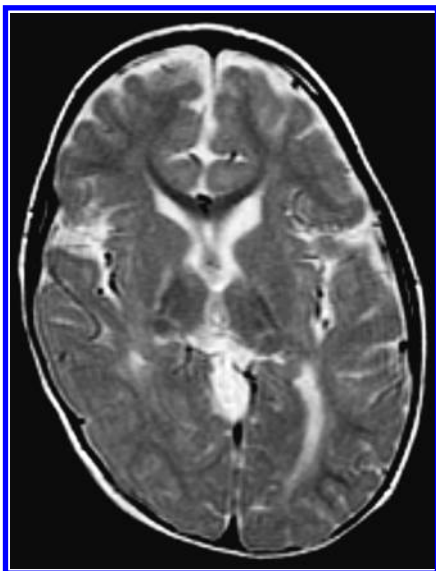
Magnetic resonance imaging of the brain. This T₂ weighted image demonstrates abnormal signal intensity in the periventricular white matter and globus pallidus bilaterally.
